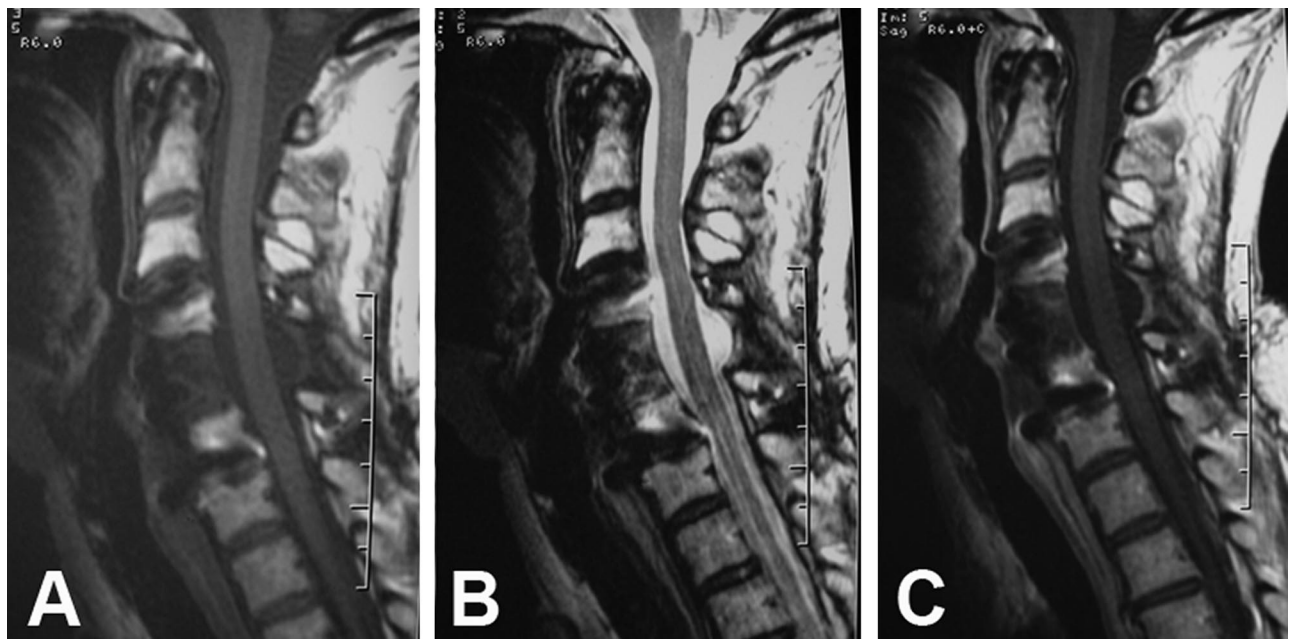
T1 (A), T2 (B), and with gadolinium contrast (C) MRI reveals no evidence of recurrent tumor.
